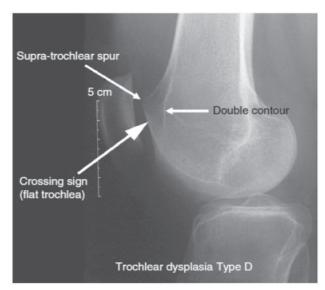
The three findings identifying trochlear dysplasia on lateral X-ray views: crossing sign, double-contour sign, and supratrochlear spur. Saggin PRF, Saggin JI, Dejour D; Imaging in Patellofemoral Instability: An Abnormality-based Approach. *Sports Med Arthrosc Rev* 2012;20:145-151.
